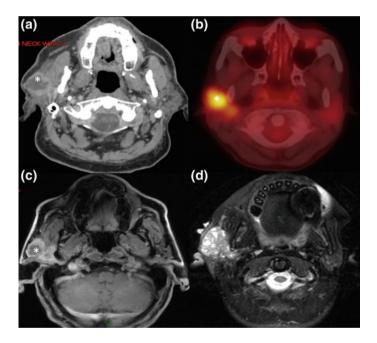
Mucoepidermoid carcinoma. a Contrast-enhanced CT. b PET-CT. c T1 fat suppressed. d T2 fat suppressed. There is a heterogeneously enhancing, partially cystic, multilobulated tumor in the superficial right parotid gland (*asterisk*). There is increased FDG avidity in Fig. 5.6c. Figure 5.6d demonstrates classic heterogeneous appearance with low T2 signal as compared to typical pleomorphic adenomas
